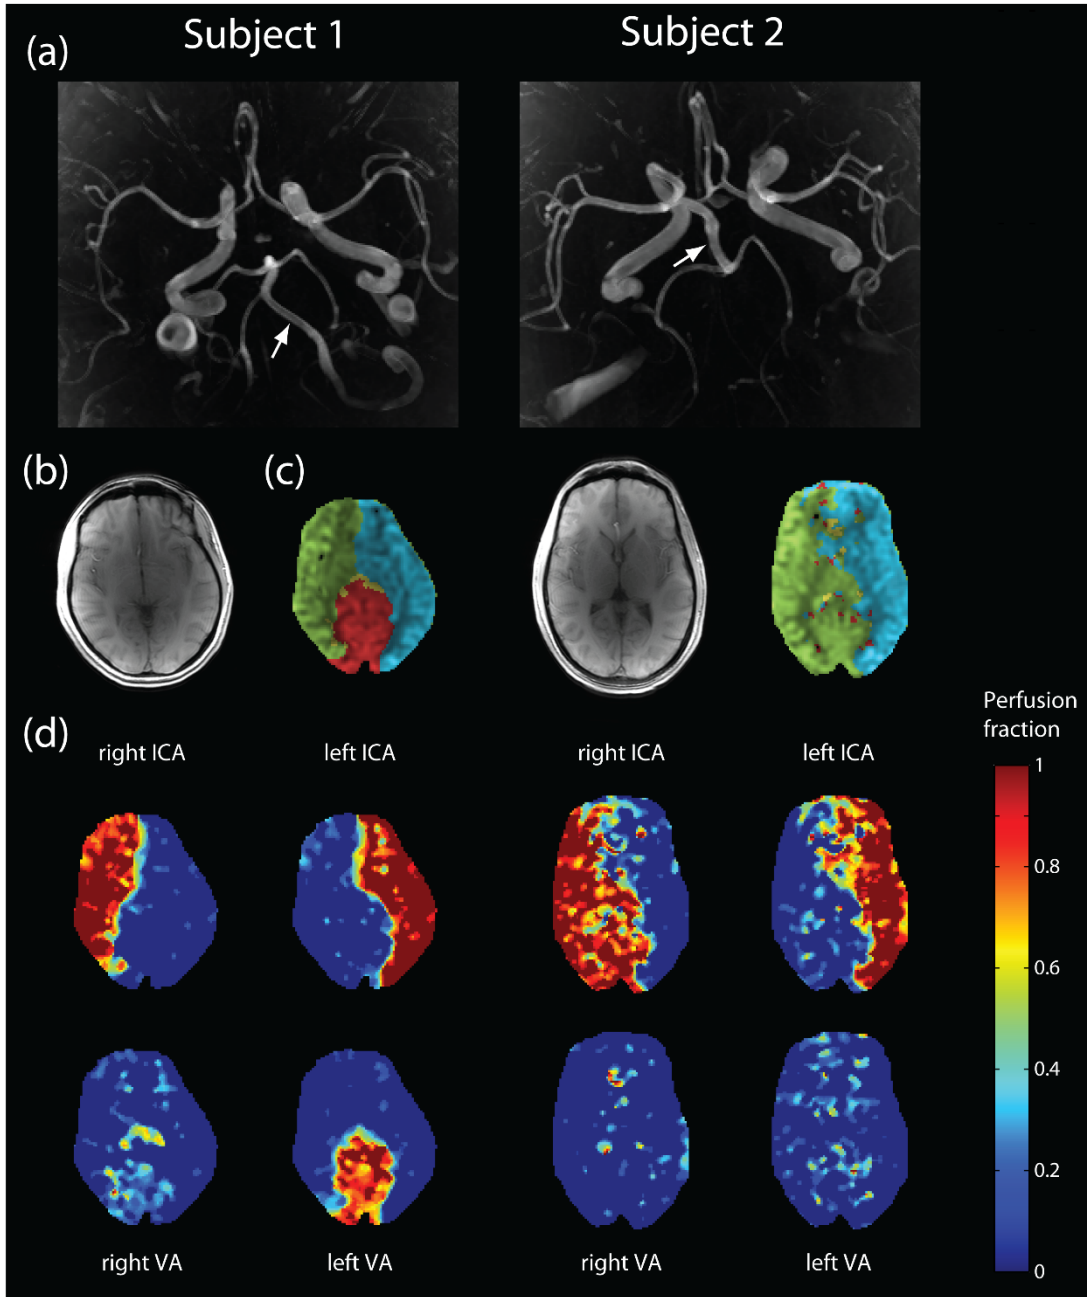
Territorial perfusion in two subjects. (a) Axial MIP of TOF angiogram. (b) T1-weighted anatomical image. (c) Color-coded perfusion map based on the following color-coding: green = right ICA, blue = left ICA, yellow = right VA, red = left VA. (d) territorial perfusion fraction map of the neck arteries. Subject 1 presented with a posterior circulation dominantly perfused by left VA. TOF confirms increased caliber of left VA (arrow). Subject 2 presented with absent basilar artery. Posterior circulation is primarily perfused by right ICA (Arrow indicates the presence of the right posterior communicating artery with an increased caliber).
